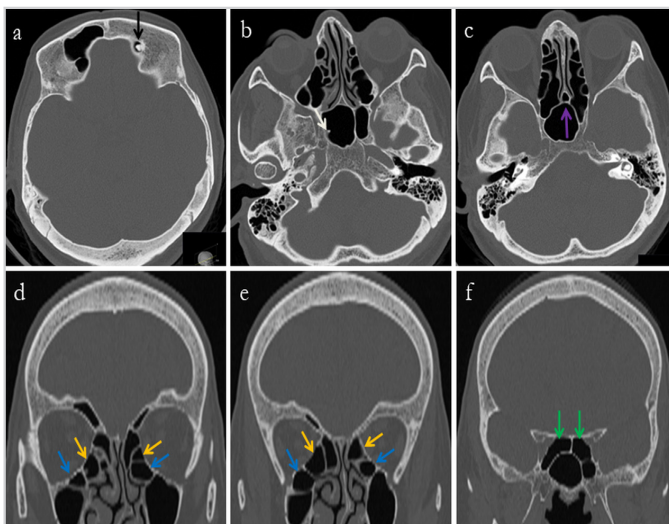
Osteoma in the left frontal sinus (black arrow), a second osteoma in the right sphenoidal sinus (white arrow) of a 64-year-old female patient. a, b, c) axial, d, e, f) coronal reformat CT images. Septum pneumatization (purple arrow), bilateral Haller's cells (yellow arrows), bilateral ethmomaxillary cells (blue arrows) and bilateral Onodi cells (green arrows) are shown
